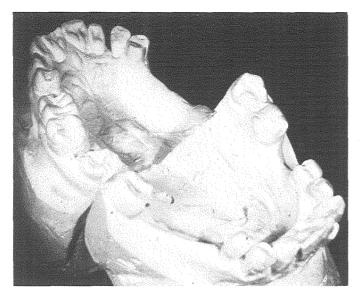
(Top and bottom). Partial denture case and roentgenograms taken before treatment in 1938.
